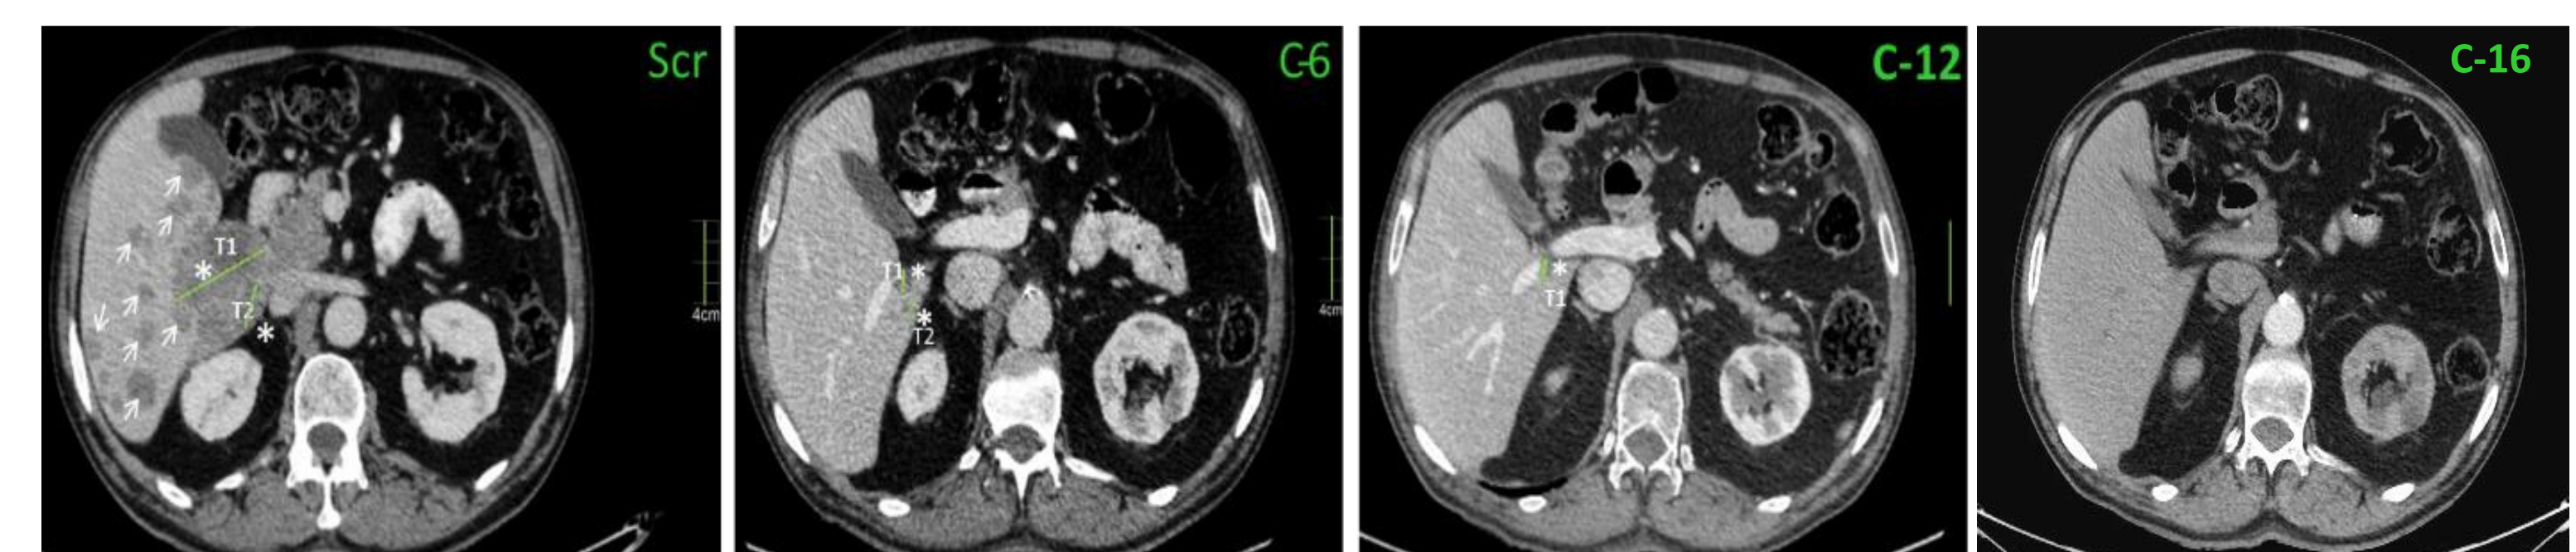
CT-Scan images of patient #102 at screening, cycle 6 (4.5 months of treatment with PE+iada combination), cycle 12 and 16 (after 6 and 10 additional cycles of iada monotherapy regimen, respectively). T1 and T2 principal lesions are followed in all images, as well as the secondary non-target lesions (indicated by arrows). Both target lesions were progressively reduced during treatment even during iada monotherapy period, and non-target lesions almost totally disappear.
